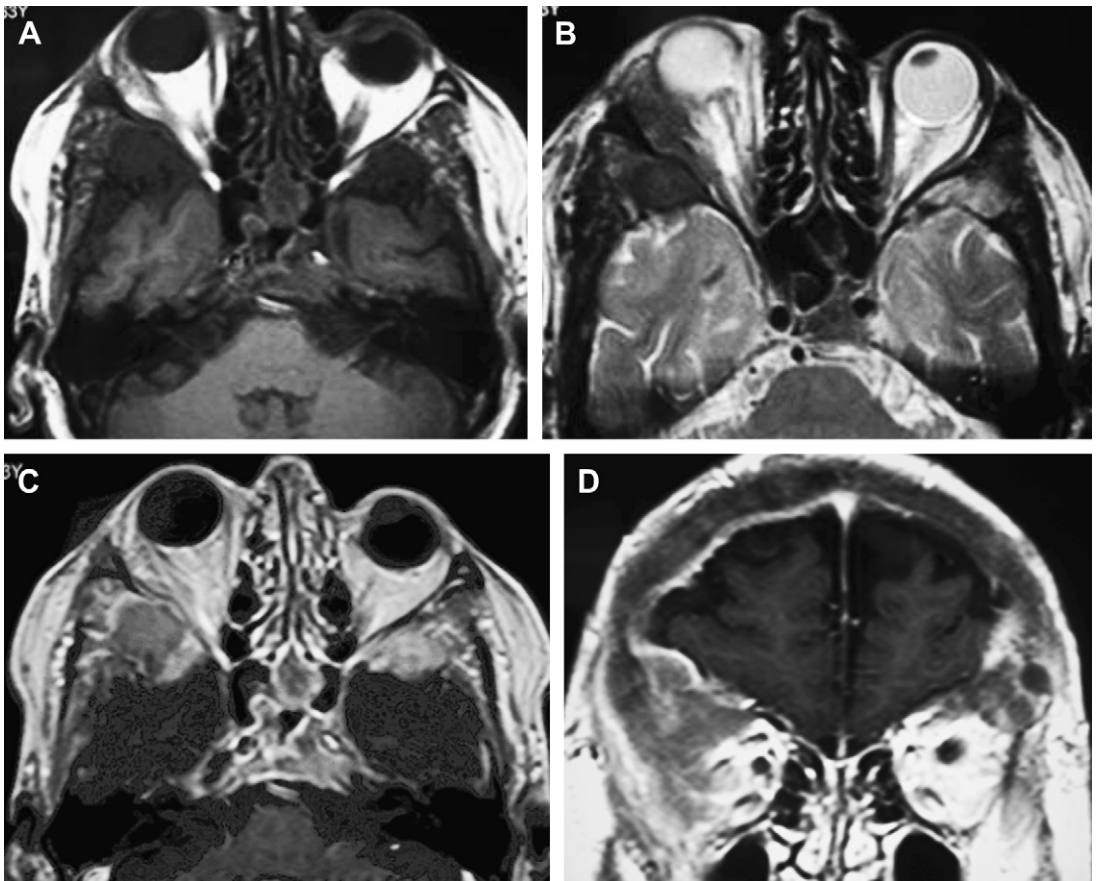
Axial T1-weighted image (A), T2-weighted image (B), and contrast-enhanced axial (C) and coronal (D) T1-weighted images show multiple predominantly sclerotic lesions (hypointense on T1-weighted and T2-weighted images) in the lateral aspect of the greater sphenoid wing, sphenoid triangle, and lateral orbital wall, which enhance vividly on the postgadolinium images. Except for the enhancement, the imaging features are similar to those shown in Fig. 21 (bone metastases from prostate cancer).
